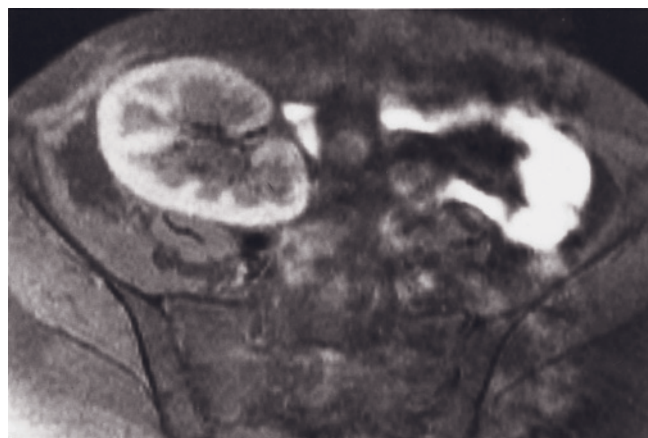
Chronic obstruction. Gradient-echo images of a subject with a chronically obstructed right kidney and a dilated nonobstructed left kidney. Cortical enhancement (capillary)-phase image (a). Normal cortical enhancement is appreciated in the left kidney, which demonstrates corticomedullary distinction. Cortical enhancement is lower in the chronically obstructed right kidney, with no definition of CMD. Low-signal-intensity gadolinium-free urine is present in both collecting systems (arrows, a). On the excretory-phase image (b), concentrated urine is excreted by the dilated nonobstructed left kidney. There is no apparent excretion by the chronically obstructed right kidney, no development of corticomedullary differentiation, and no significant changes in parenchymal signal intensity from the cortical enhancement phase. (Reprinted with permission from Semelka RC, Hricak H, Tomei E, Floth A, Stoller M: Obstructive nephropathy: evaluation with dynamic Gd-DTPA enhanced MR imaging. *Radiology* 175: 797-803, 1990.)
